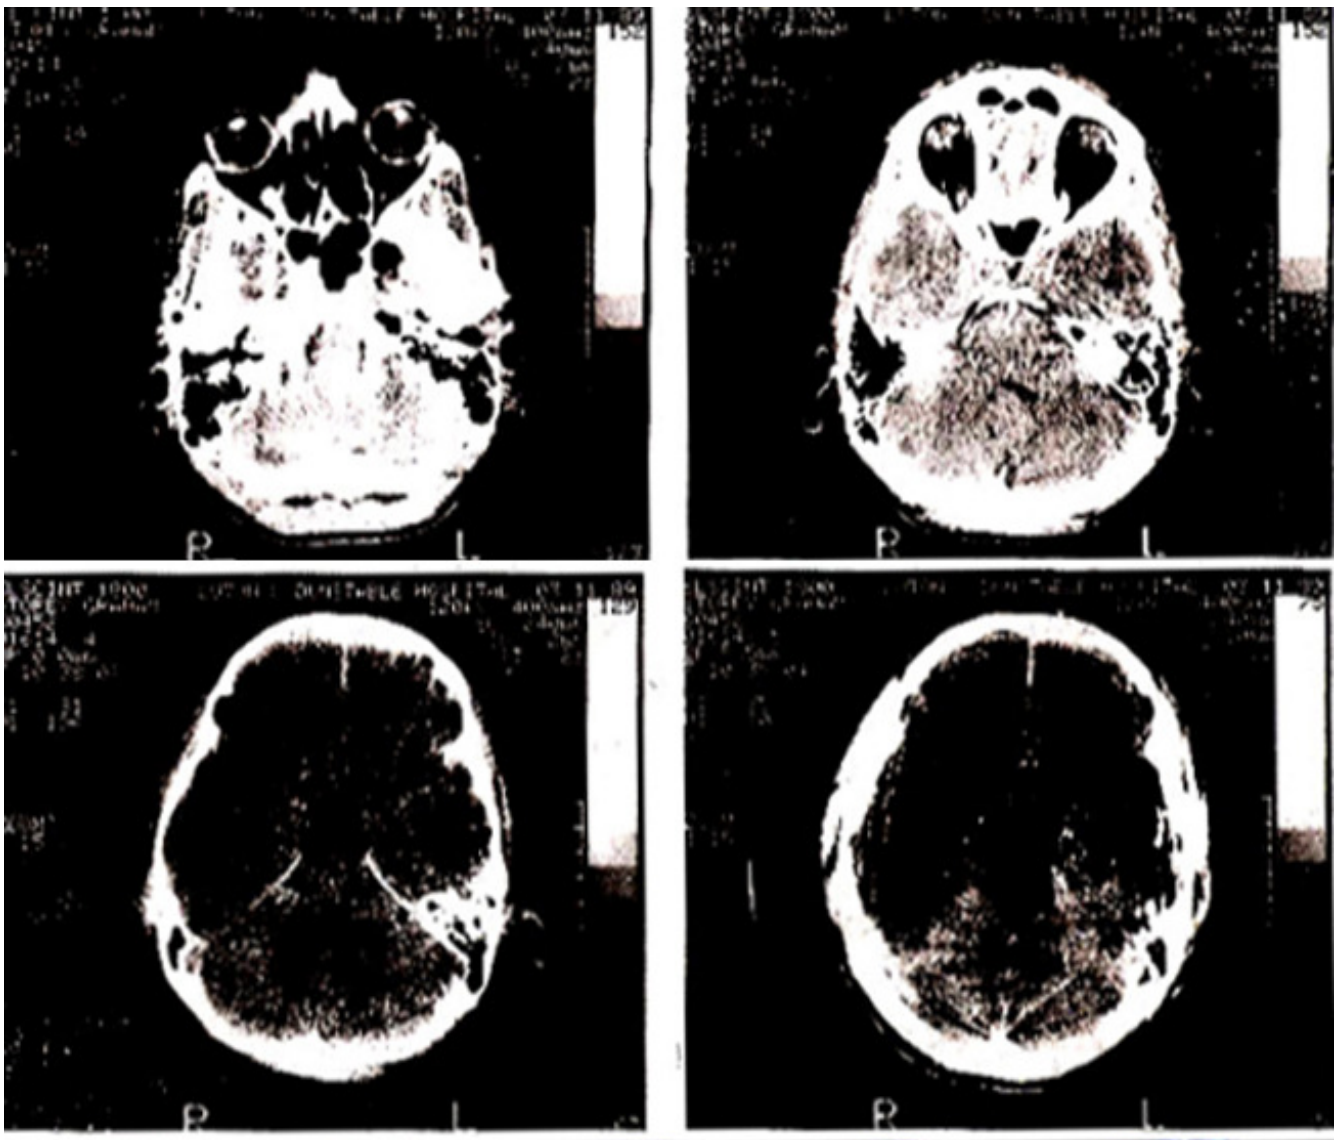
Repeat CT scan .
